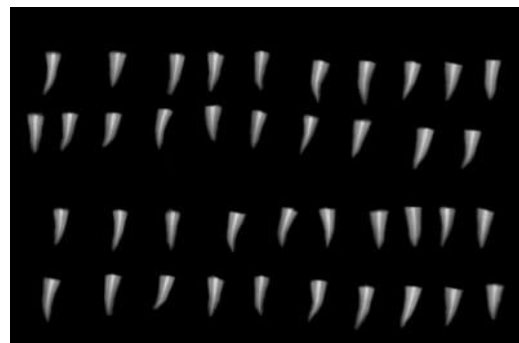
Radiographic evaluation of obturtation
